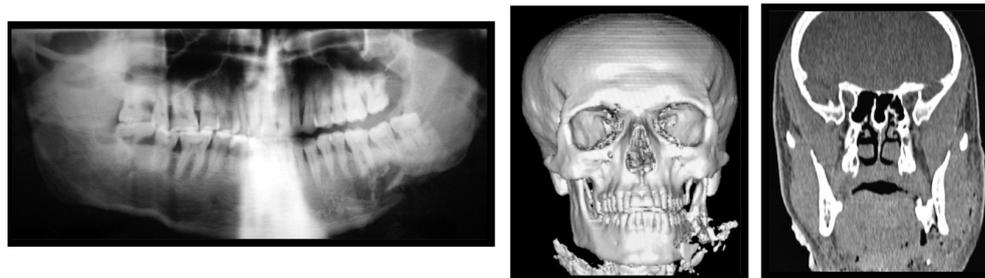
Panoramic radiograph and computed tomography images taken after the injury
